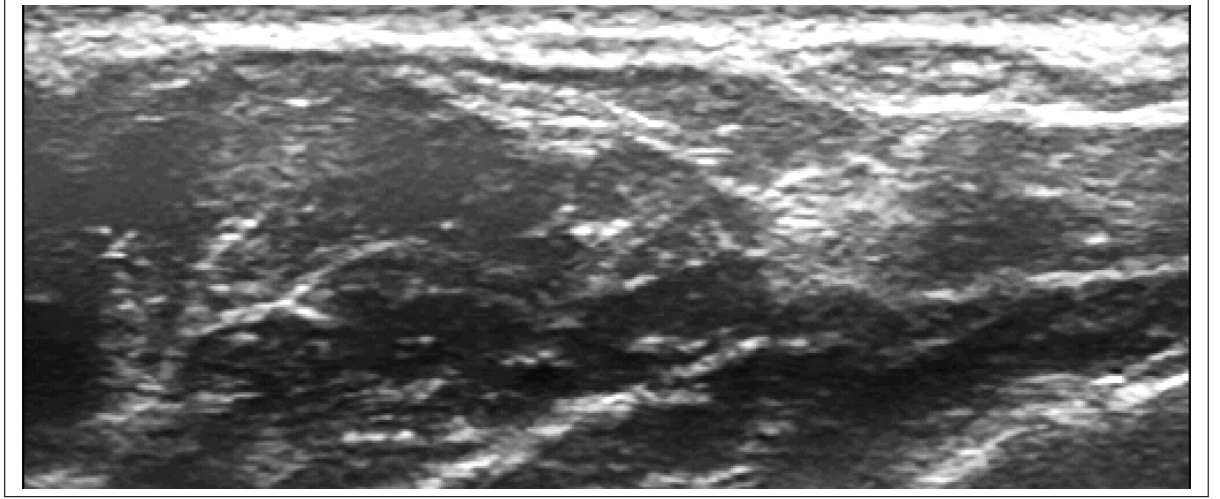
Example of a grayscale ultrasound image
